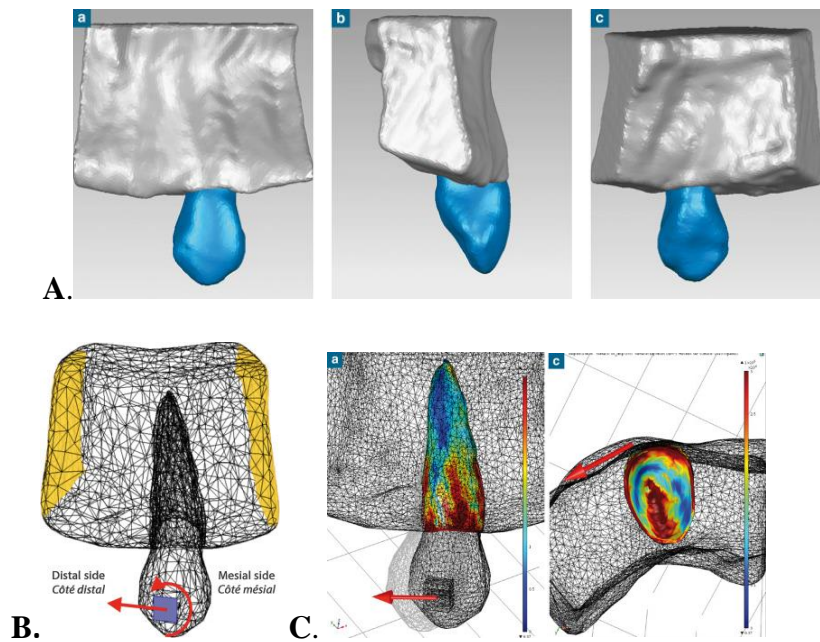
A. 3D reconstruction of tooth model extracted from a CBCT B. Meshed Model C. FEA results (Bouton et al., 2017)
